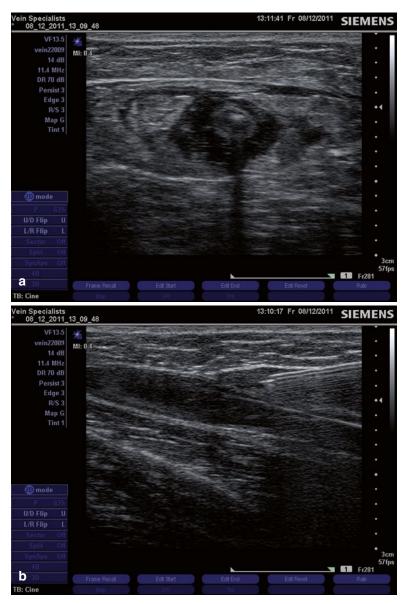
Diagnostic ultrasound images showing catheter placement during endothermal venous abiation. (a) Transverse view. (b) Longitudinal view (Courtesy: Mark N. Isaacs)
